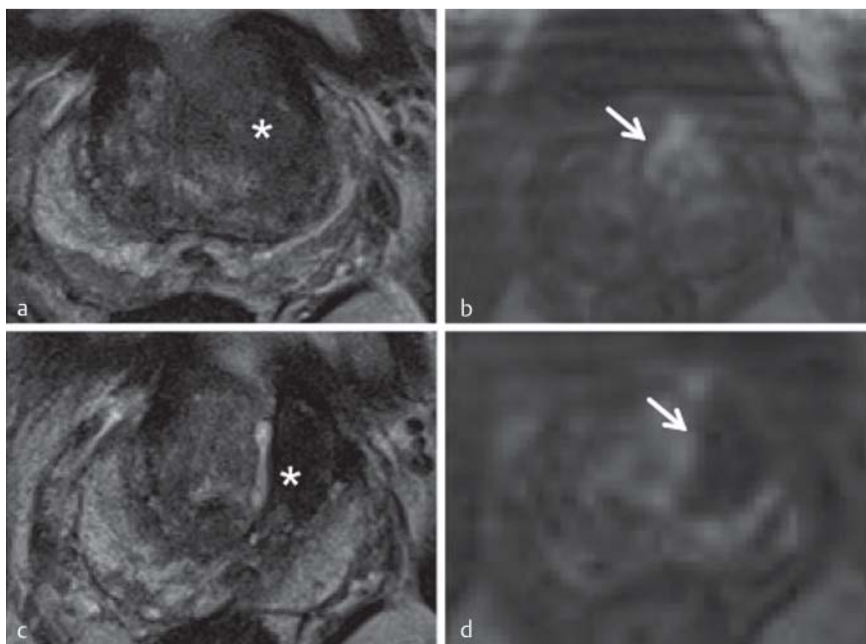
Patient with prostatic cancer (*) (Gleason score: 3 + 3 = 6) in the transitional zone treated with ultrasound-guided IRE. The preprocedural pre-contrast a and postcontrast b MRI scans show the tumor in the ventral left prostatic lobe. Follow-up MRI examinations six months after IRE demonstrate a hypointense area in the ablation zone c and a sharply demarcated perfusion defect in the same area d (arrow) on T2-weighted images.
